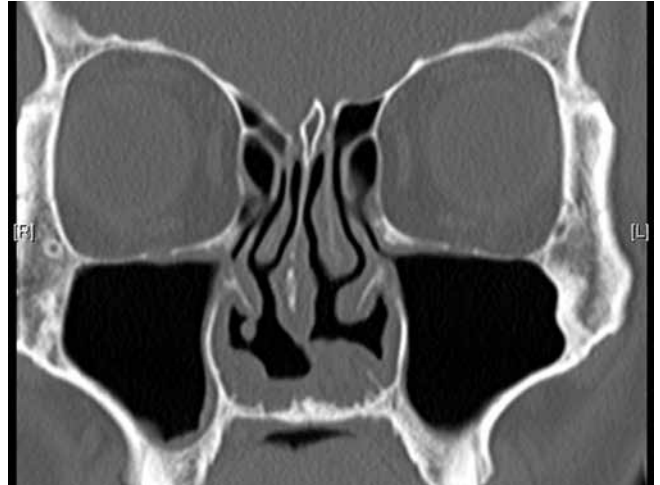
The sinus CT after submucosal implantation of Medpor® showed more appropriate volume of nasal cavity.
